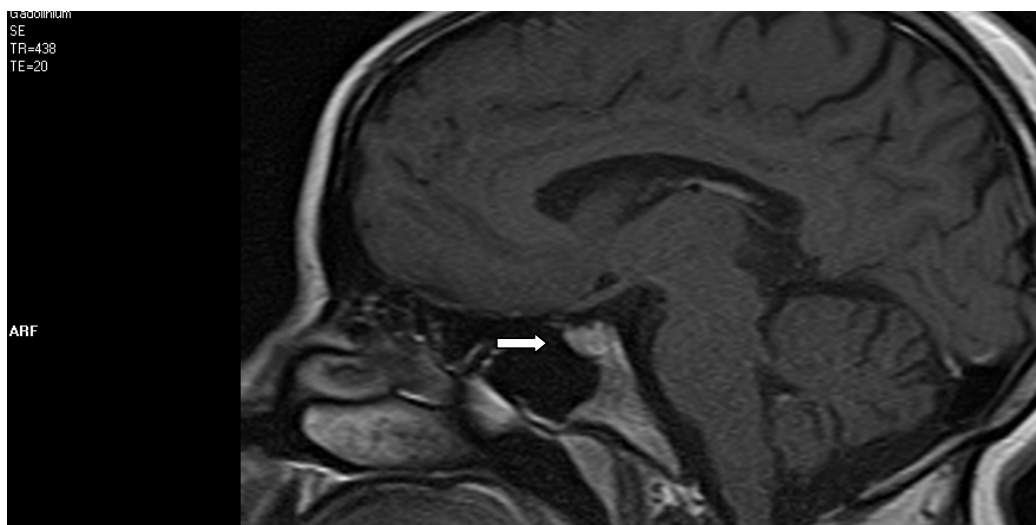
MRI Brain sagittal T1 WI with contrast showing microadenoma for 32 years old male
